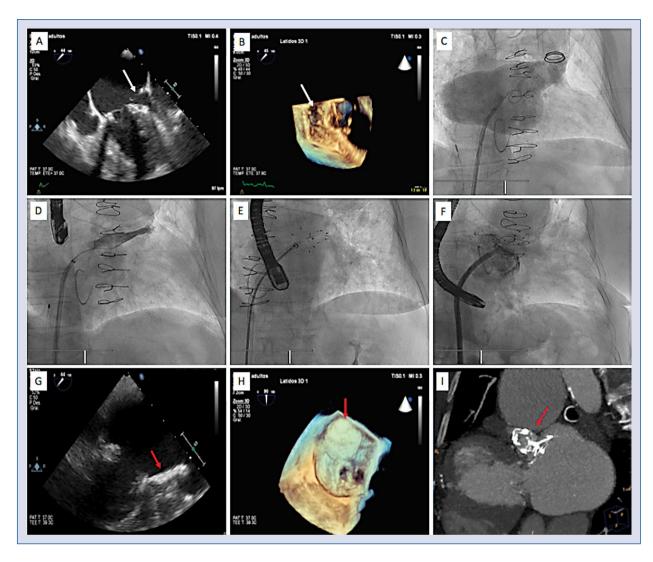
A. Two-dimensional transesophageal echocardiography (2D TEE) view showing the incomplete left atrial appendage (LAA) closure (white arrow); B. Three-dimensional transesophageal echocardiography (3D TEE) image showing the ostium of the incomplete LAA closure (white arrow); C. Fluoroscopic image: left atrium angiogram using a pigtail catheter; D. Fluoroscopic image: selective injection with AL1 catheter finding LAA location; E. Fluoroscopic image: Ultraseal device deployment; F. Fluoroscopic image: final result with complete sealing of LAA; G. 2D TEE view: LAA closure with Ultraseal device (red arrow); H. 3D TEE image: Ultraseal device proximal sail view covering the LAA (red arrow); I. Computed tomography scan image: Ultraseal device position sealing the LAA (red arrow).
